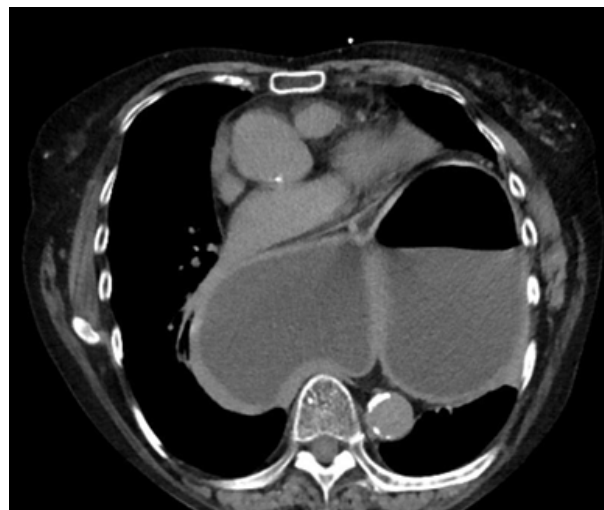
CT of Abdomen and Pelvis showing large hiatal hernia with gastric volvulus.
